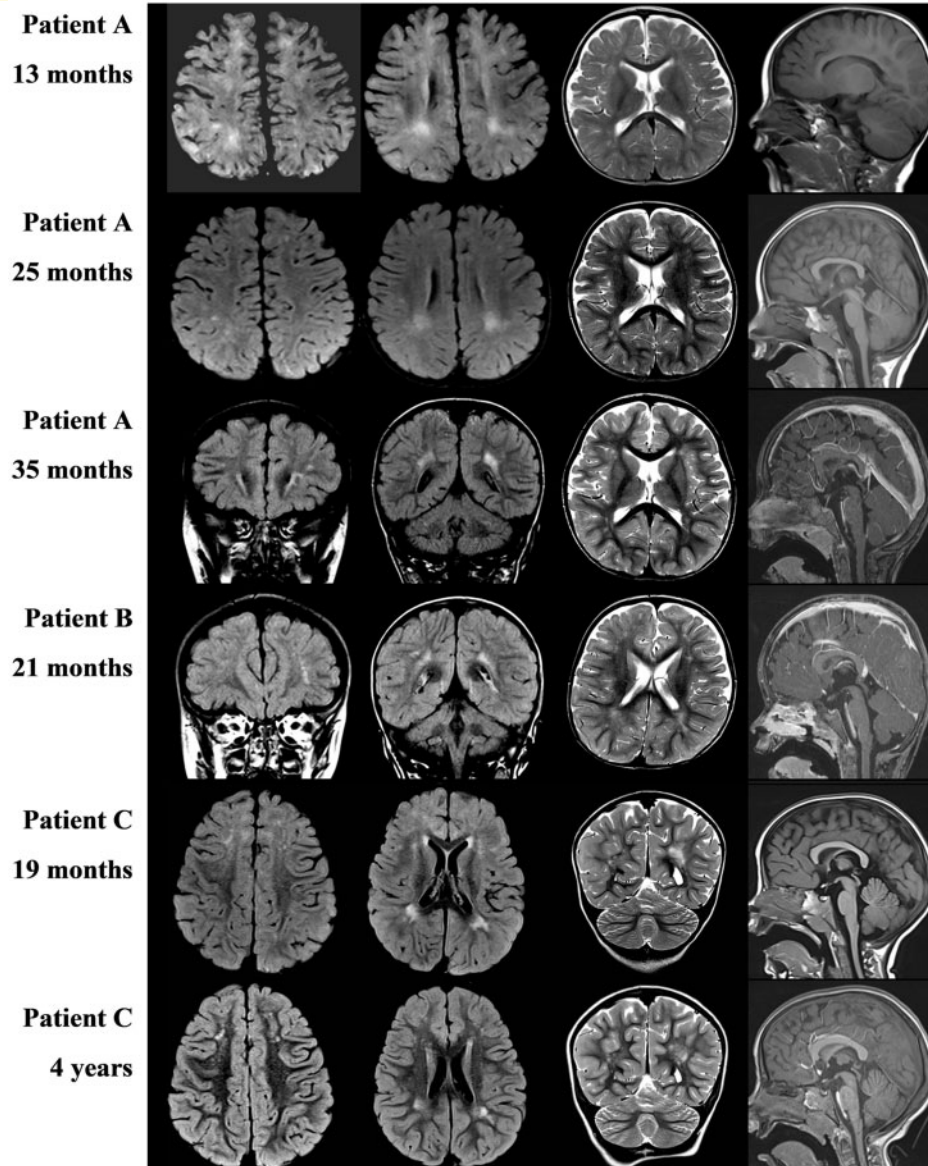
Brain MRI results obtained from seven GALNT2-CDG patients at different ages. MRI scans showed white matter lesions in scans from Patients A–F but not in scan from Patient G. Patient age at the time of the MRI scan is shown. Columns 1 and 2 depict axial FLAIR images (or coronal FLAIR for Patient A at 35 months, Patient B, and Patient F). Column 3 depicts T₂-weighted images in axial view (or coronal view for Patients C–E). Column 4 depicts sagittal T₁-weighted images (with intravenous contrast for Patient A at 35 months and Patient B).
